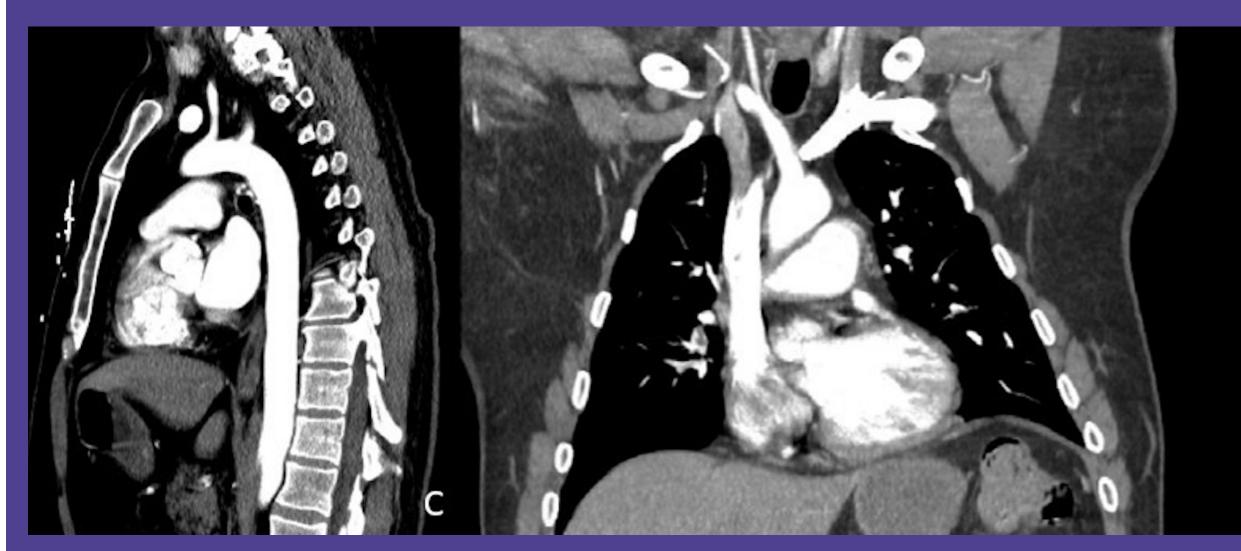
CT scan images at a follow-up visit after one month of therapy with anticoagulation. There is a significant decrease in clot burden with near resolution as seen in the sagittal (left) and coronal (right) views respectively.
